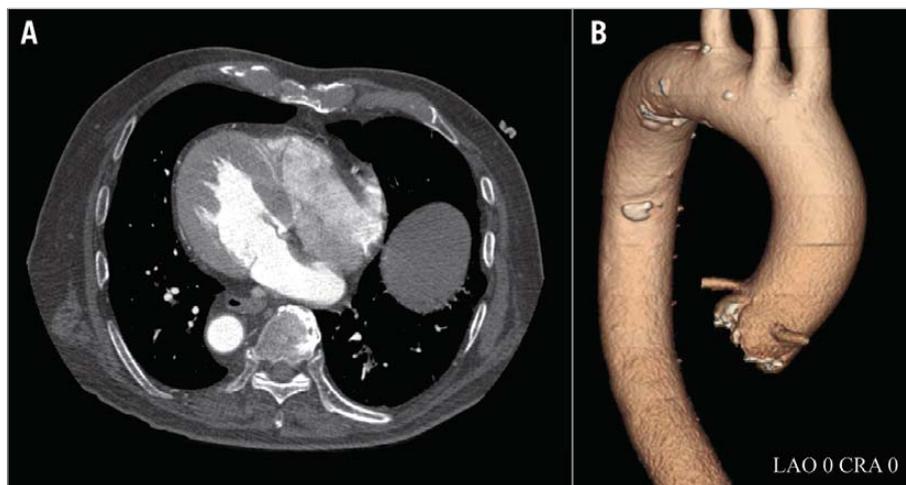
Computed tomography. A) Right-sided left ventricle and descending aorta. B) 3D image of the right-sided aortic arch. CRA: cranial oblique; LAO: left anterior oblique
